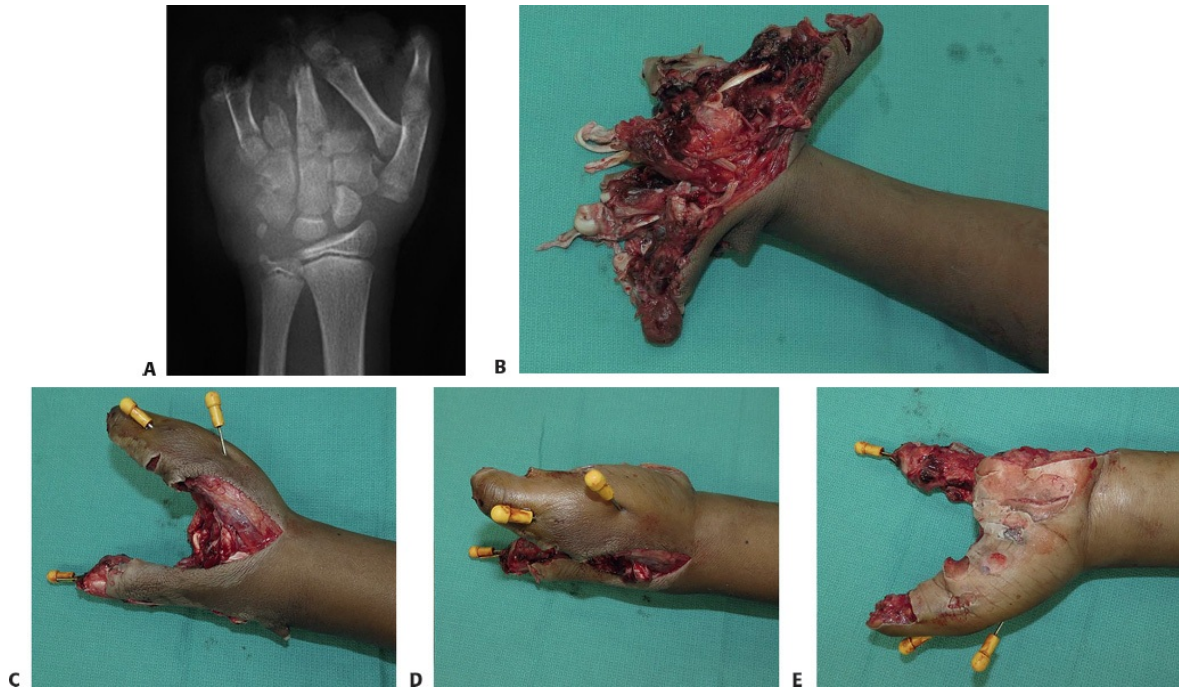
• A,B. Preoperative radiograph and clinical photograph, respectively, of a 12-year-old boy who sustained a bomb-blast injury to the left upper extremity. C–E. Images after left hand radical debridement, open reduction and internal fixation of the left thumb metacarpal using K-wires, and left index finger metacarpal transposition to the small finger and fixation with K-wires.
